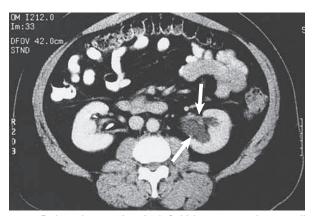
Delayed excretion in left kidney secondary to distal calculus. Contrast-enhanced CT scan shows dilated left renal pelvis (arrows).
